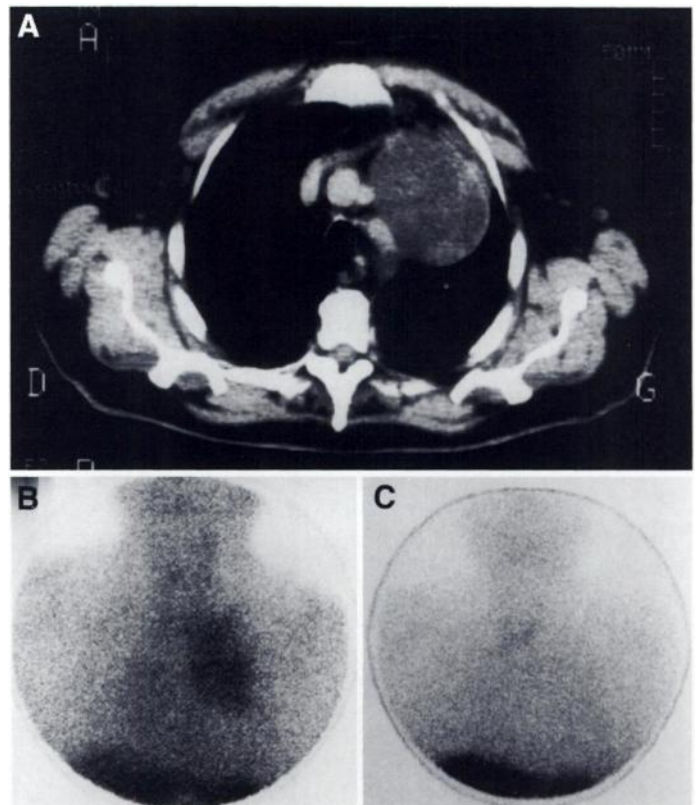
(A) CT scan after contrast enhancement in a patient with lymphangioma accurately defines the extent of the tumor mass involving the upper anterior mediastinum and the upper lobe of the left lung. Heterogeneity within the tumor mass is accurately defined by the different densitometric measurements, with a necrotic area surrounded by viable neoplastic tissue. (B) Anterior view of the chest 4 hr after [^{111}In -DTPA-D-Phe 1]-octreotide administration shows peptide uptake within the lesion. (C) There is no tracer accumulation in the 24-hr images.
